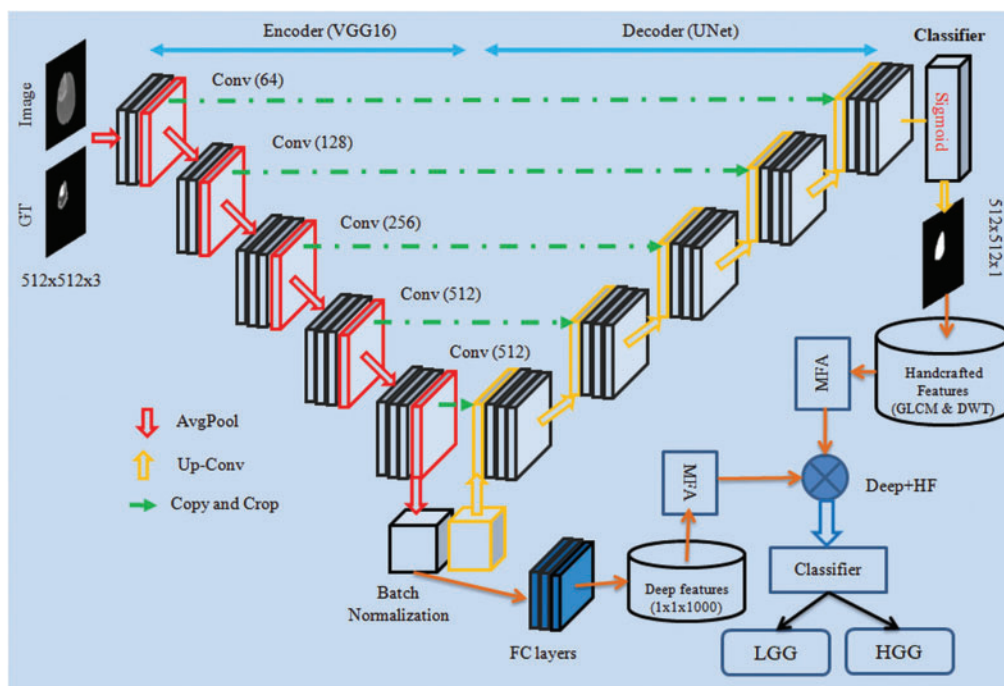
CNN framework for segmentation and evaluation of BT from 2D MRI slices
